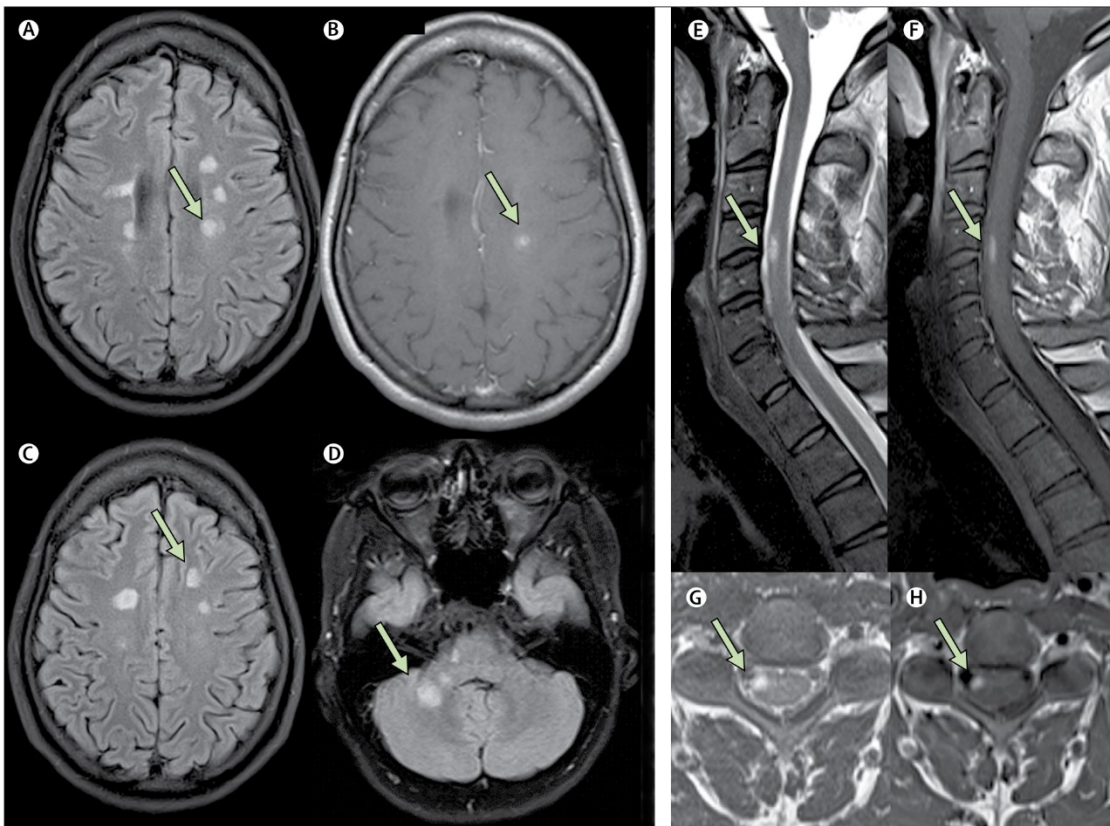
MRI images showing features and location of MS-lesions in the cerebrum and spinal cord. *A*, *C* and *D* are Fluid Attenuated T2 images showing periventricular, juxtacortical and infratentorial lesions respectively (arrows). *B* shows a T1 weighted image after contrast administration, where a single periventricular lesion exhibits contrast enhancement. *E* and *F* show sagittal images of the spinal cord on T2 and T1 (post-contrast) images. Arrows here point to a single anterior/lateral spinal cord lesion. There is contrast enhancement in this lesion, as seen in *F*. *G* and *H* show axial scans, also T2 and T1-post contrast, showing the lesion as being located in the right anterolateral area. Figure taken from Brownlee, Hardy (5).
